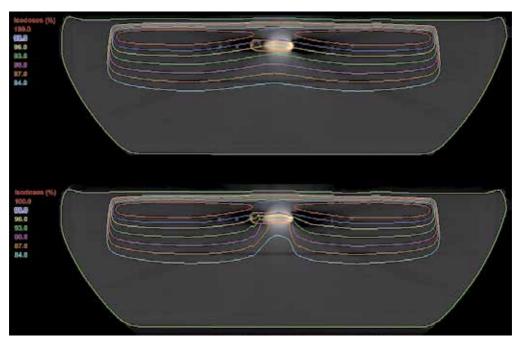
Treatment plan dose distributions in the axial plane at 6 MV x-rays involving the Boston Scientific ICP Altrua® 60 EL model S606 in water; (Top) with no density correction and (Bottom) following appropriate heterogeneity correction
